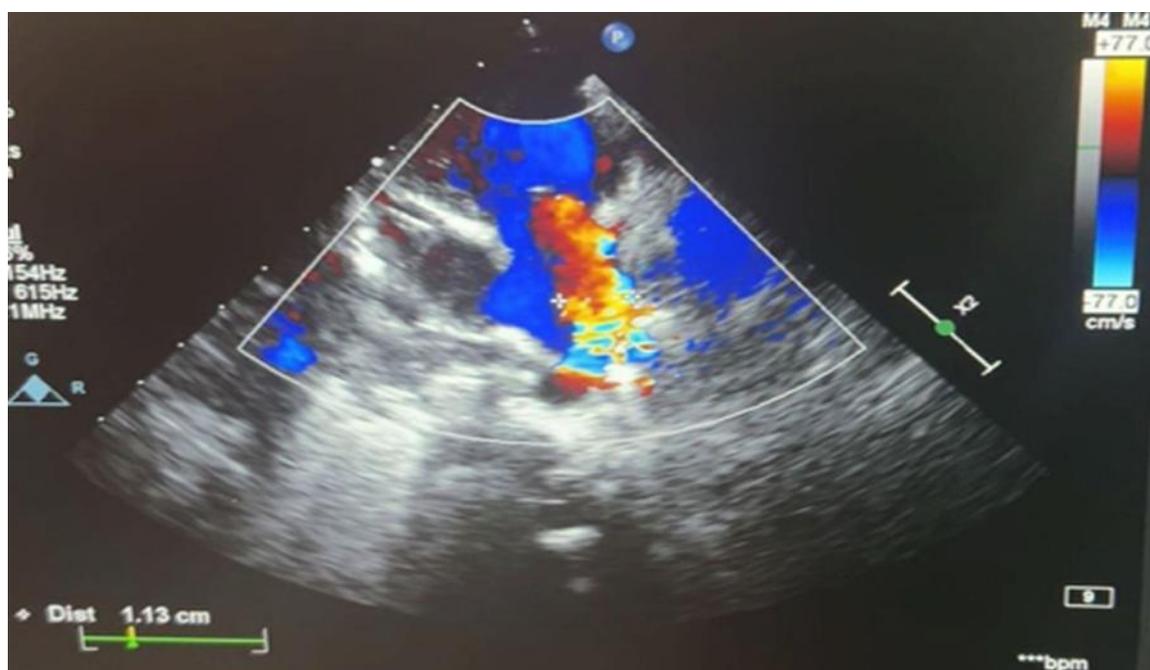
Patent ductus arteriosus in color Doppler mode in a one-week-old newborn.
